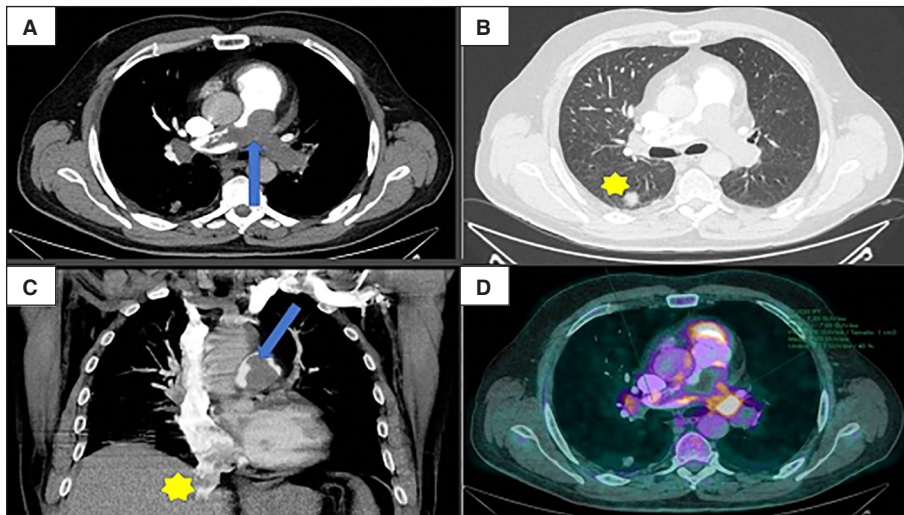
A and B. Axial section of chest CT-angiography showing PTE at both pulmonary arteries (arrow) and pulmonary nodule at the right lower lobe (RLL) level (asterisk). C. Coronal section of chest CT-angiography showing almost complete involvement of the left pulmonary artery (arrow) and reflux of the inferior vena cava (asterisk). D. Axial section of PTE showing increased uptake at the level of the pulmonary arteries.
